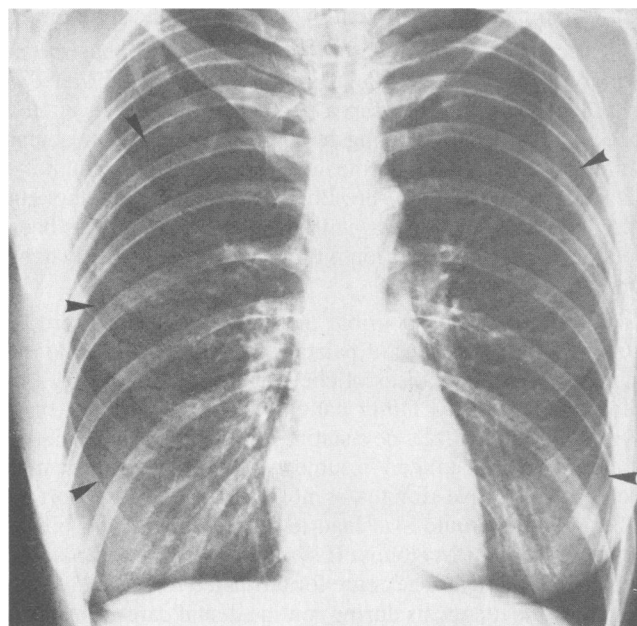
A chest x-ray film taken several hours before presentation shows bilateral pneumothoraces. The arrows outline lung markings.
